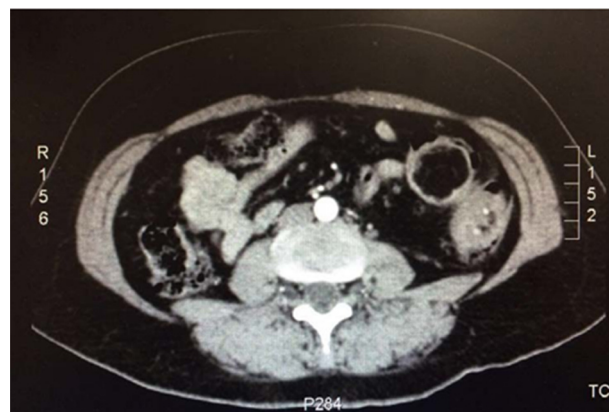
Abdominal CT with left colon thickening.
